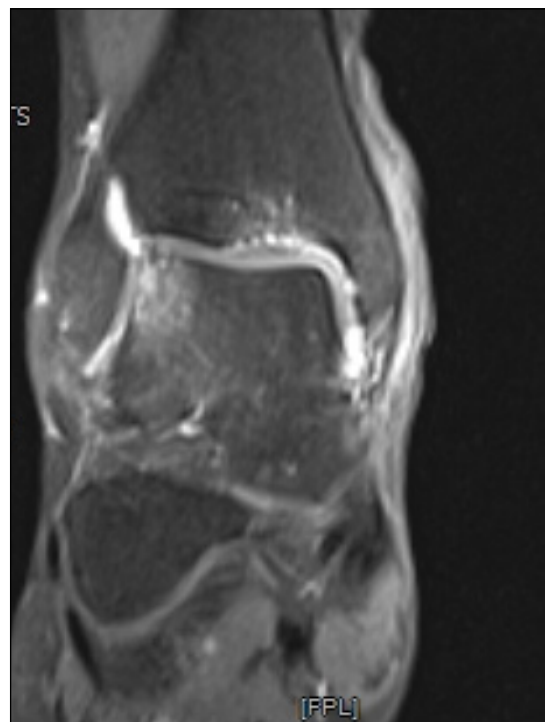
10-year follow-up post-operative MRI of the lesion treated with AMIC.
